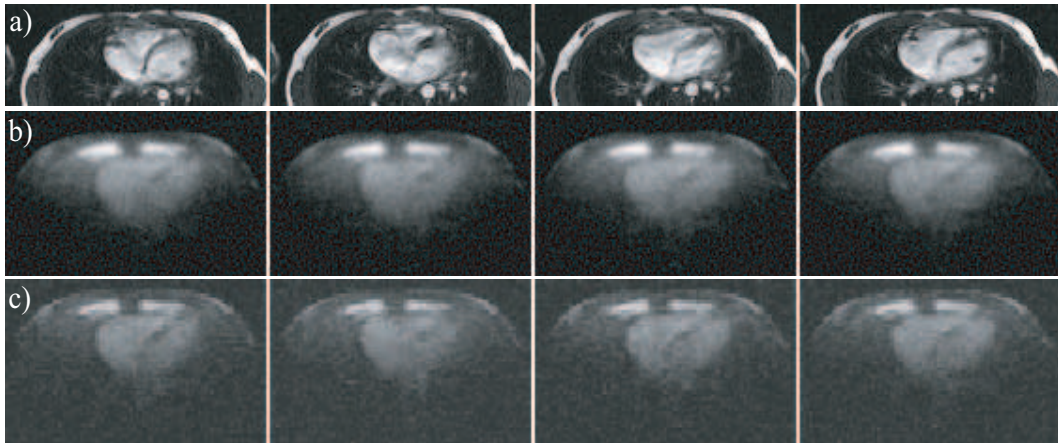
Transverse MRI images of the heart of a healthy volunteer. Time series of ^{23}Na radial (a) and cartesian (b) gradient echo images. The images show four heart phases. Right and left ventricle are visualised together with the myocardium. The SNR in the ventricle is 1.6 times larger in the radial technique compared to the cartesian technique.
